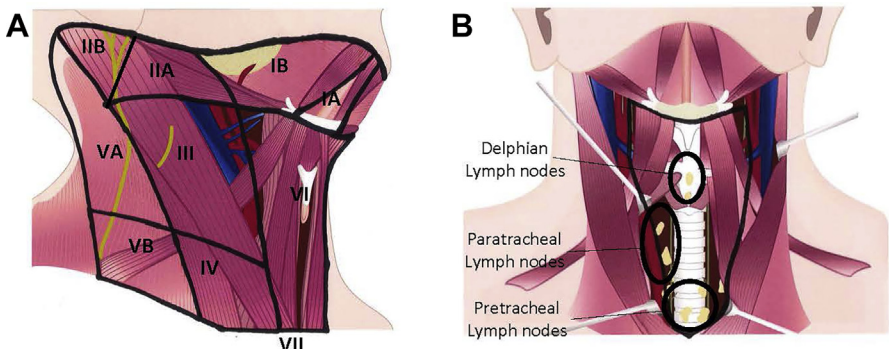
(A) Cervical lymph node levels I-VII. (B) Depiction of central lymph nodes with thyroid removed. (Courtesy of Kate Christison-Lagay, PhD, New Haven, CT.)
